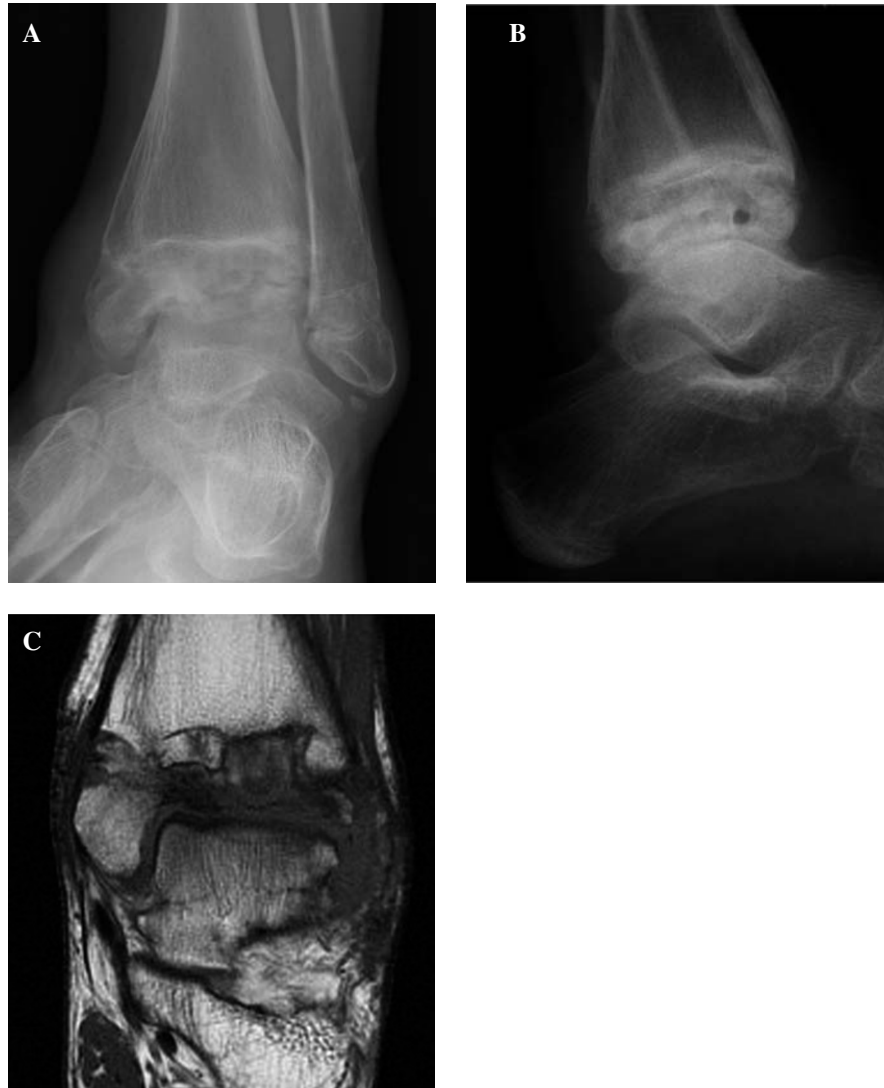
Anteroposterior (A) and lateral (B) radiographs and MRI scan (C) after removal of the hardware. Changes consistent with osteonecrosis and collapse of the distal tibial epiphyses along with chondrolysis of the tibiotalar joint are seen.
